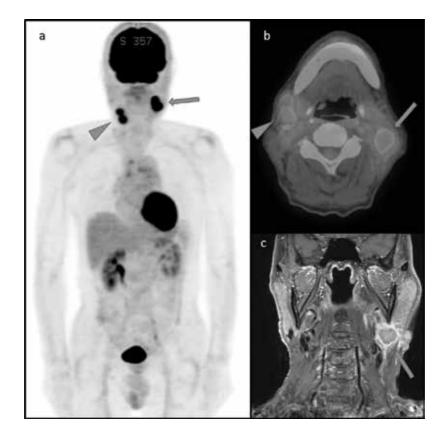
(a). PET MIP image. (b). PET/CT fusion image. (c). T1-weighted MRI using gadolinium-based contrast (GdT1) image. Very strong uptake of FDG (SUVmax: 15.8, arrow) is seen in the region corresponding to the left parotid tumor on the MRI image. Uptake is seen in the region of the right internal jugular lymph nodes (SUVmax: 10.2, arrow head). Parotid cancer or cervical lymph node metastasis is suspected.
